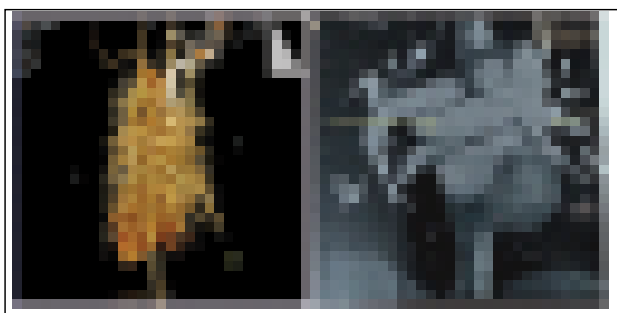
CT angiogram showing supra cardiac TAPVC.
